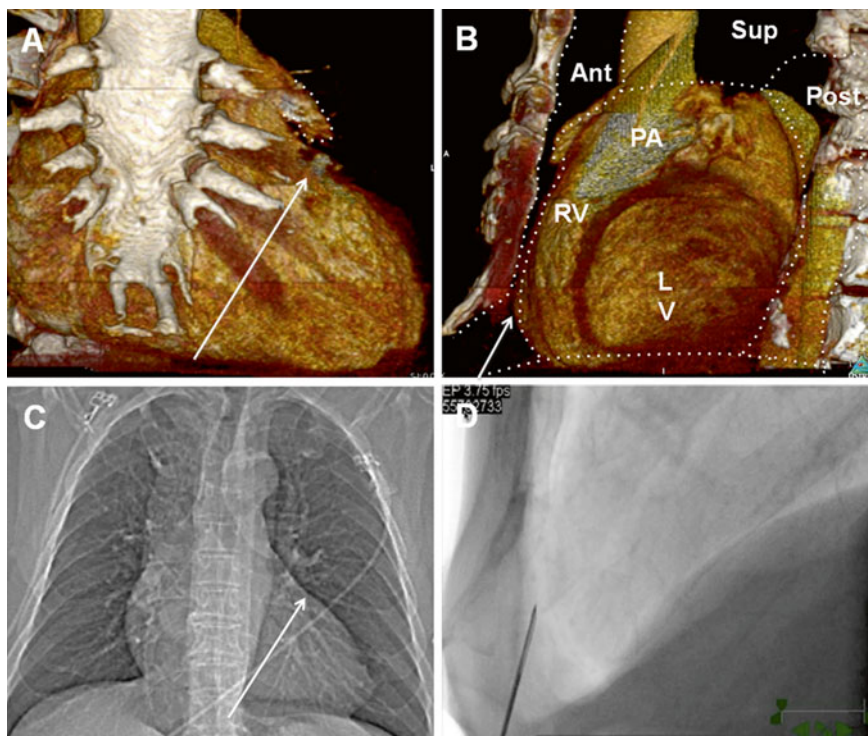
Utility of Cardiac CT angiography (CTA) for estimation of the direction and depth of the pericardial needle. Pericardial access for LAA ligation utilizing the LARIAT™ suture delivery device requires an anterior access approach into the pericardial space. As seen in the anteroposterior view (AP) of the 3D reconstruction of the CT angiogram (panel a), the LAA (delineated by the dashed line) is lateral to the pulmonary artery (PA) and appears to be in front of the hilum. The needle is directed (direction of the arrow) just lateral to the LAA that is generally toward the left shoulder. In the fluoroscopic image, the needle (arrow) would be directed just lateral to the hilum (panel c). The lateral view of the 3D reconstruction of the CT angiogram (panel b) demonstrates the virtual space of the anterior mediastinal space (Ant). The needle (arrow) is directed through the sternocostal triangle that allows for the needle to pass under the xyphoid process and above the diaphragm into the anterior mediastinal space, thus avoiding damage to the diaphragm and avoiding abdominal organs. The 90° left lateral fluoroscopic view allows for the needle to be advanced to the myocardial border (panel d). *Ant* anterior mediastinal space, *Sup* Superior mediastinal space, *Post* posterior mediastinal space, *RV* right ventricle, *PA* pulmonary artery, *LV* left ventricle (Reproduced from Koneru et al. [14] with permission)
